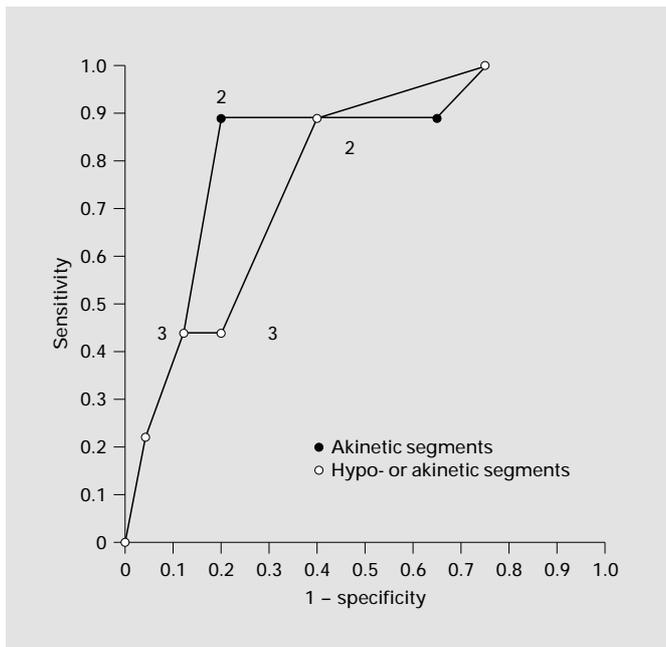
Receiver-operating characteristic curve analysis to predict reversible dysfunction in 34 patients with patent target vessel at follow-up by the number of viable segments by low-dose dobutamine echocardiography. Test performance was optimized by exclusion of hypokinetic segments from the analysis which increased the area under the curve from 0.78 for hypokinetic or akinetic segments to 0.83 for akinetic segments only.
